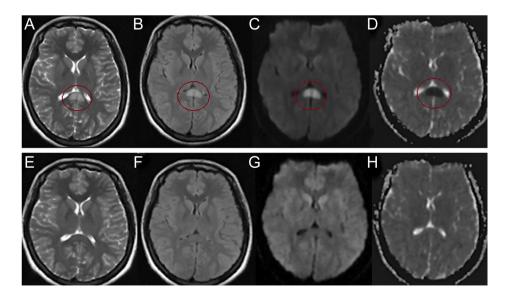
Magnetic resonance image reveals an oval-shaped T2-weighted/fluid-attenuated inversion recovery hyperintense focal lesion in the mid-splenium of the corpus callosum (A-B, circle) with restricted diffusion showing a hyperintense signal on diffusion-weighted imaging (C, circle) and a hypointense signal on the apparent diffusion coefficient map (D, circle). Third-week follow-up magnetic resonance imaging with T2-weighted imaging (E), fluid-attenuated inversion recovery (F), diffusion-weighted imaging (G), and apparent diffusion coefficient mapping (H) reveal the complete disappearance of the callosal lesion.
